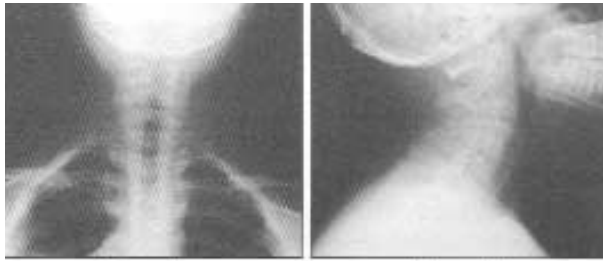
g-h: In the cervical radiograph at postoperative 6th month (g, h) solid fusion mass can be observed.
